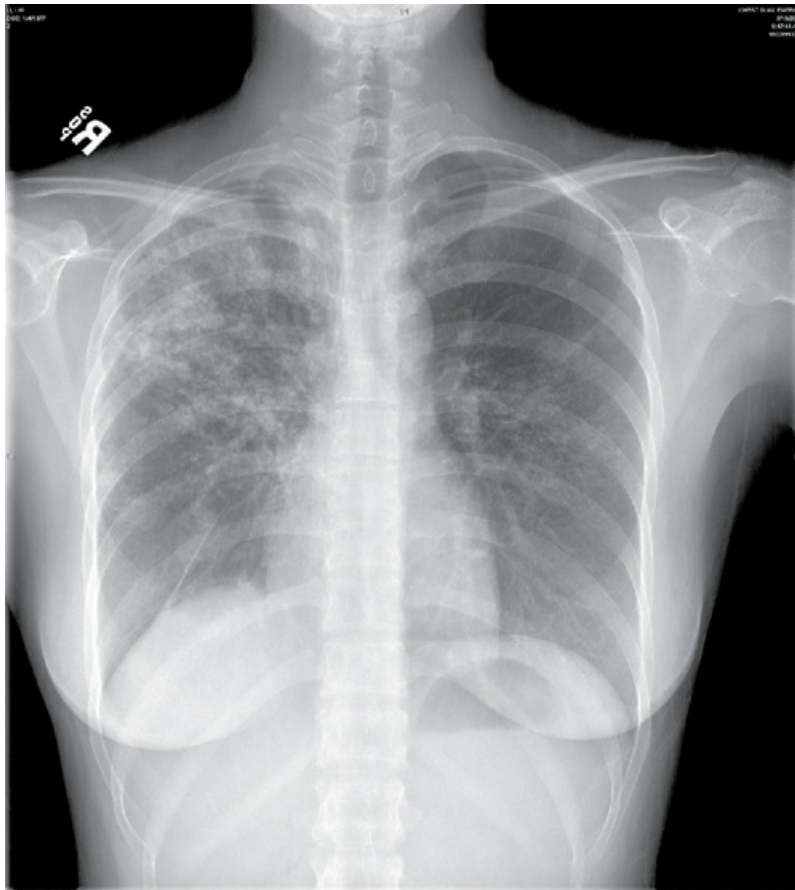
Chest radiograph of patient with reactivation tuberculosis. Note infiltrates in the right lung, primarily in the right upper lobe.
